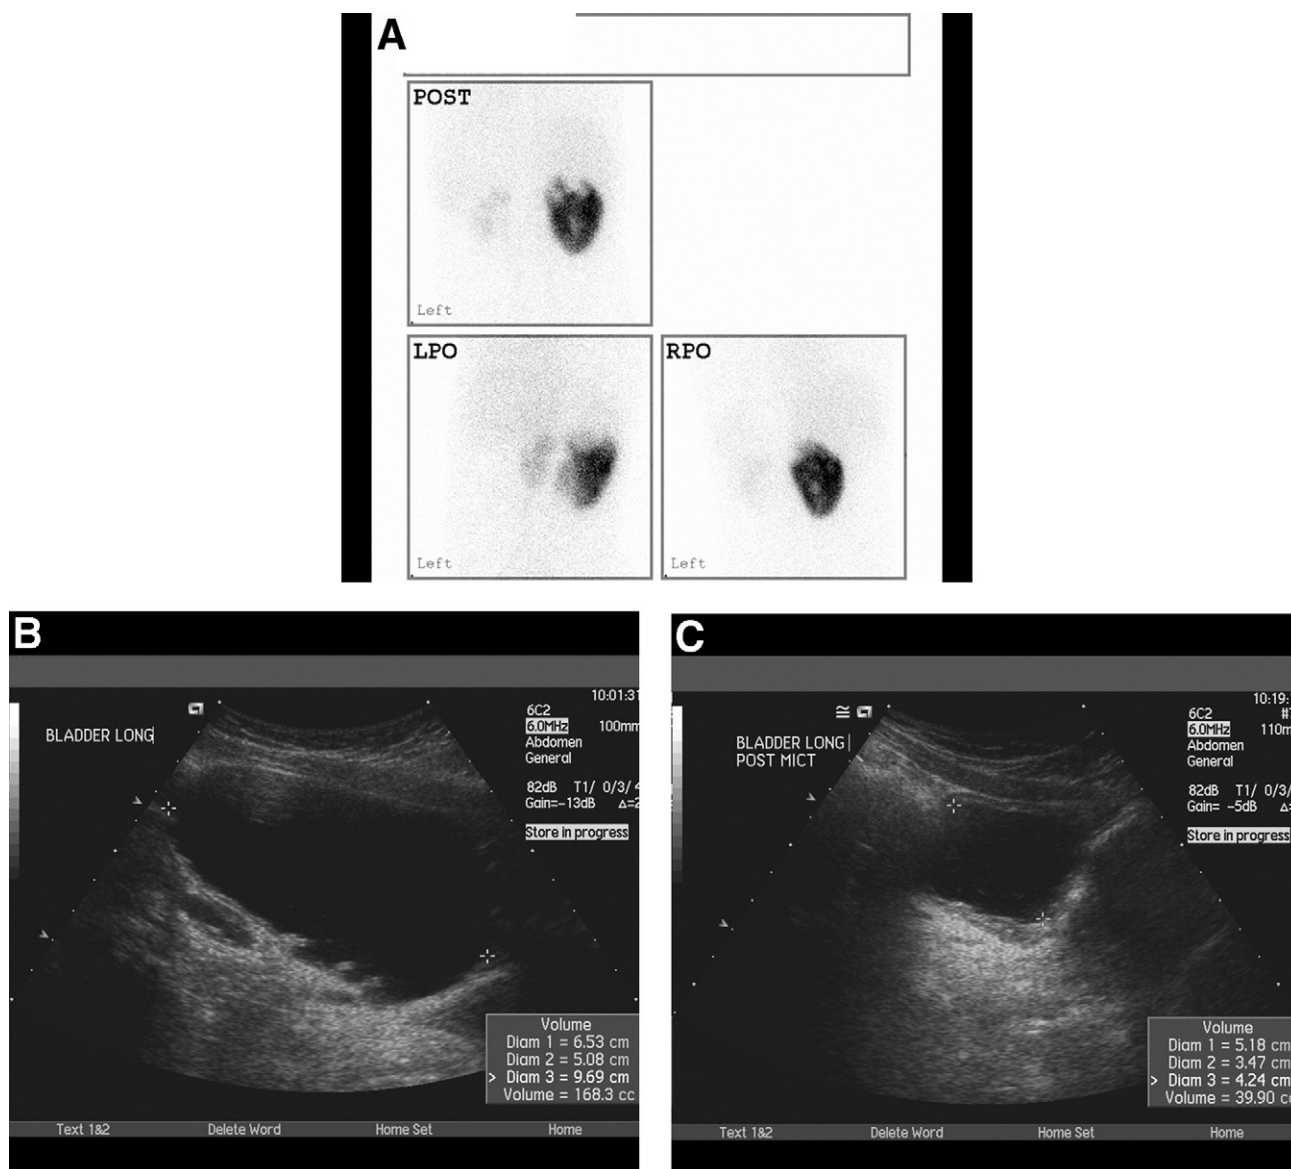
DMSA scan in a 12-year-old girl with spinal dysraphism, recurrent UTI, and bladder dysfunction. The ultrasound showed a thickened bladder wall with small diverticula and focal thinning at the upper pole of the left kidney. The DMSA scan shows several renal scars bilaterally with a very poorly functioning left kidney and a damaged but much better functioning right kidney. The differential function is left kidney <5%, right kidney >95%.
